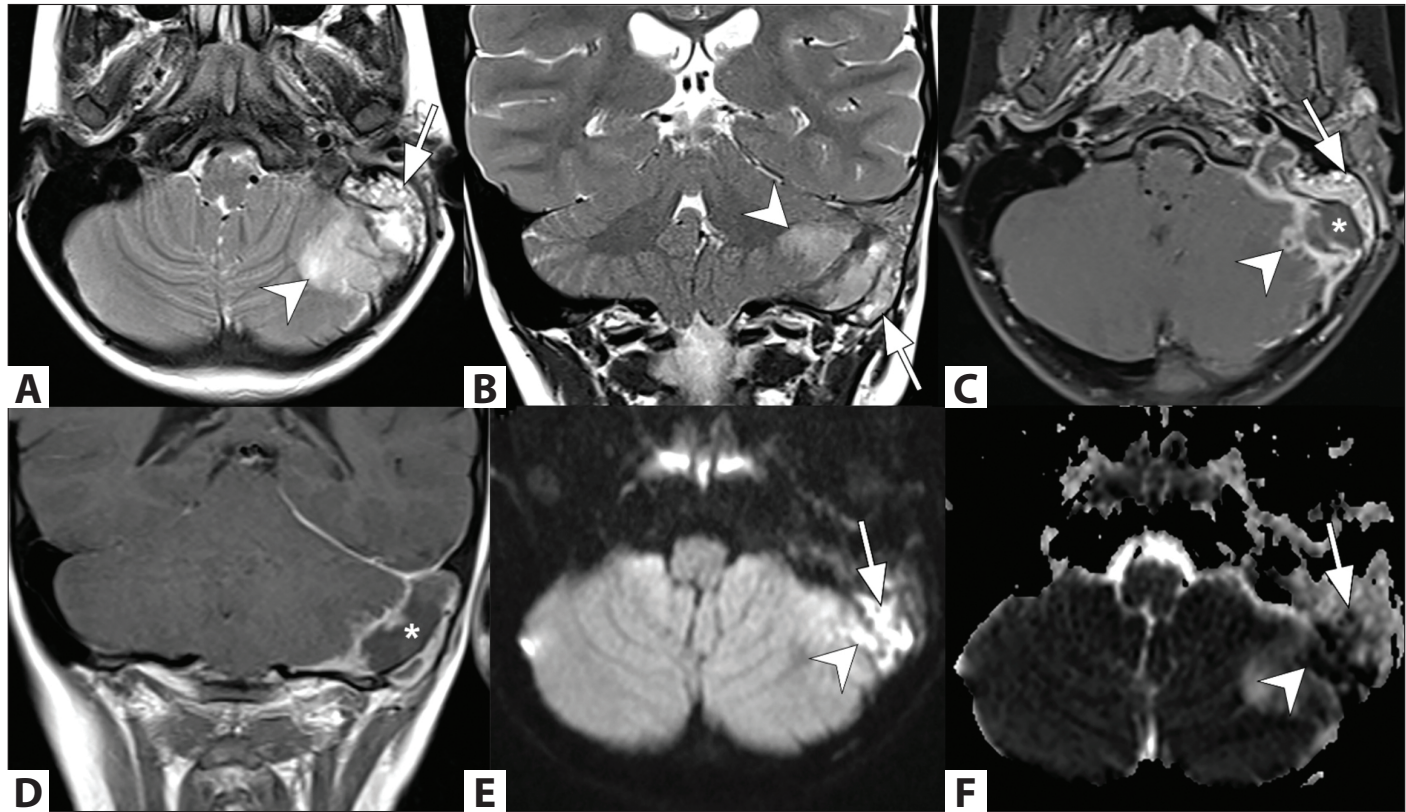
Axial (A) and coronal (B) T2-weighted images show effusion in mastoid cells (white arrow) and high T2 signal in the cerebellum (arrow head). Post-contrast T1-weighted axial (C) and coronal (D) images show contrast enhancement in the left mastoid cells (white arrow), filling defect in the left transverse sinus (asterisk) and microabscess in the left cerebellar hemisphere (arrow head). Diffusion-weighted images (E) and ADC maps (F) show diffusion restriction in mastoid cells (arrows) and sigmoid sinus (arrow head).
